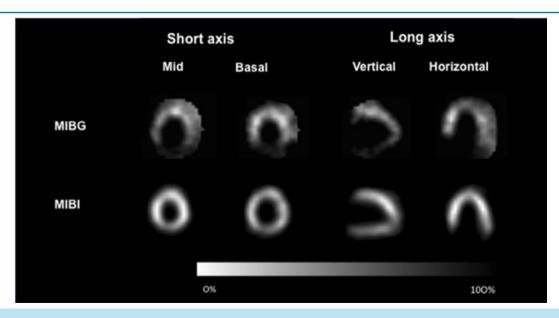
Representative image of <sup>123</sup>I-MIBG (upper panel) and <sup>99m</sup>Tc-sestamibi SPECT (lower panel) showing normal Tc99m-Sestamibi uptake and severe <sup>123</sup>-I-MIBG uptake defects in the segments of the inferior, inferior-lateral, and septal inferior walls, indicating the presence of viable but denervated myocardium.
